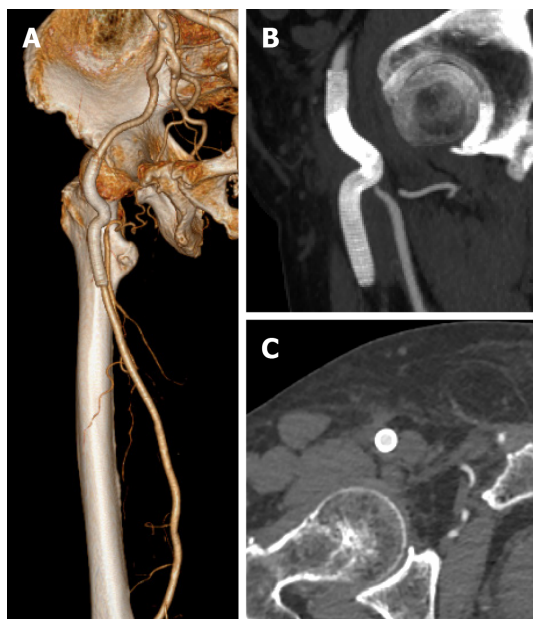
Computed tomography angiography at the 1-year follow-up. A: Stent-grafts were patent without any endoleaks; B and C: The previous surrounding hematoma was completely absorbed.
